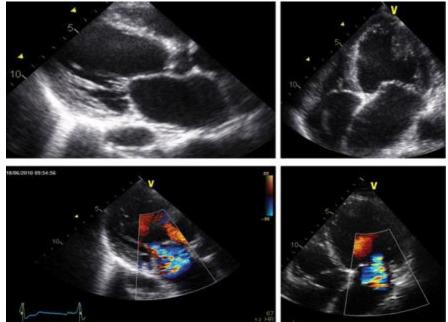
Symmetric mitral valvular distortion and central jet of ischaemic mitral regurgitation. Upper panel: parasternal long-axis view (left) apical four-chamber view (right). The left ventricle is dilated and spherical. Symmetric tethering of the leaflets is present, inducing large tented area and coaptation distance. Lower panel: corresponding images showing the color jet, originating and directed centrally (2).
